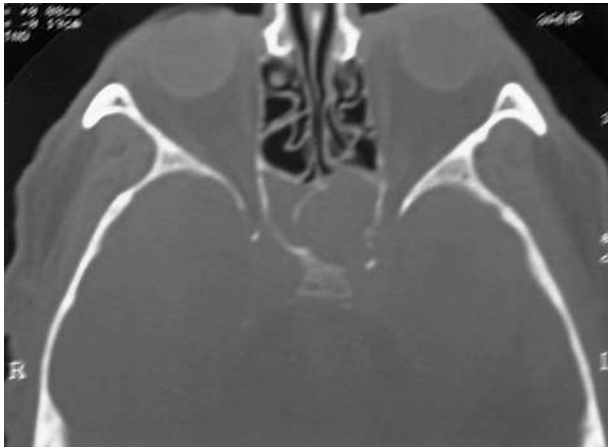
Preoperative axial CT scans showing the mucocele filling and expanding of the left sphenoid sinus.
